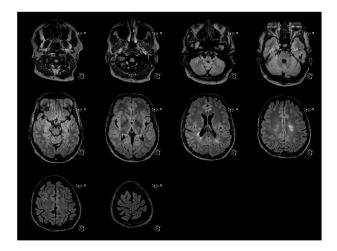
MRI FLAIR scan from patient 79 in 2016, 35 slices displayed. Exam performed at ICNAS, classified as C.
